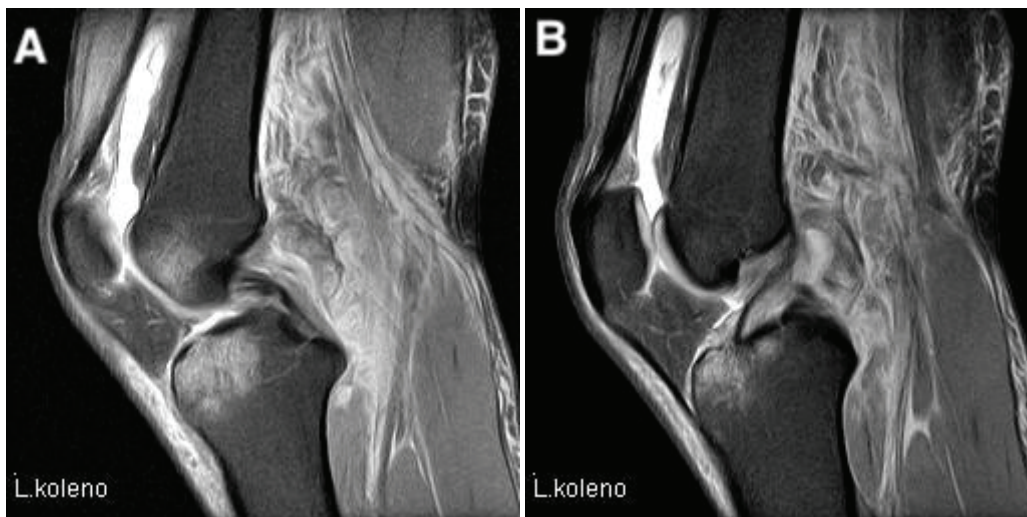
Preoperative magnetic resonance imaging (MRI): A) posterior cruciate ligament; B) anterior cruciate ligament.
